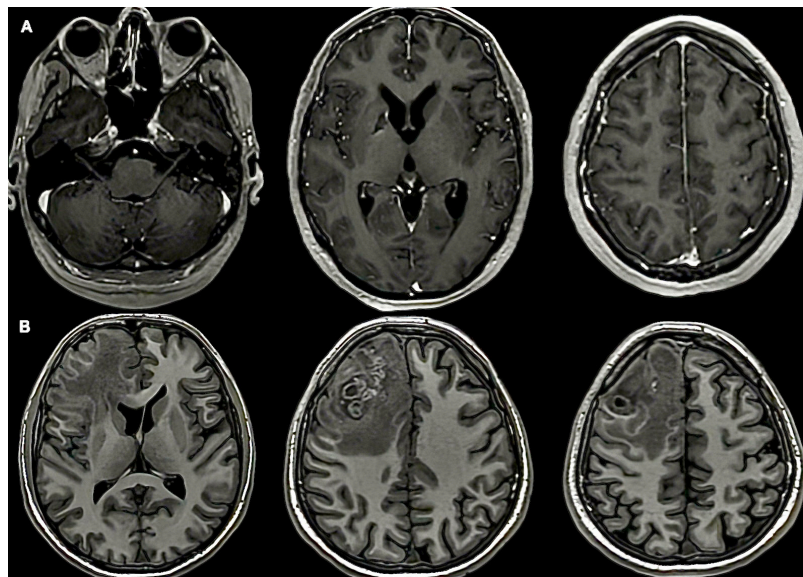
Magnetic resonance images of central nervous system tuberculosis patients.
